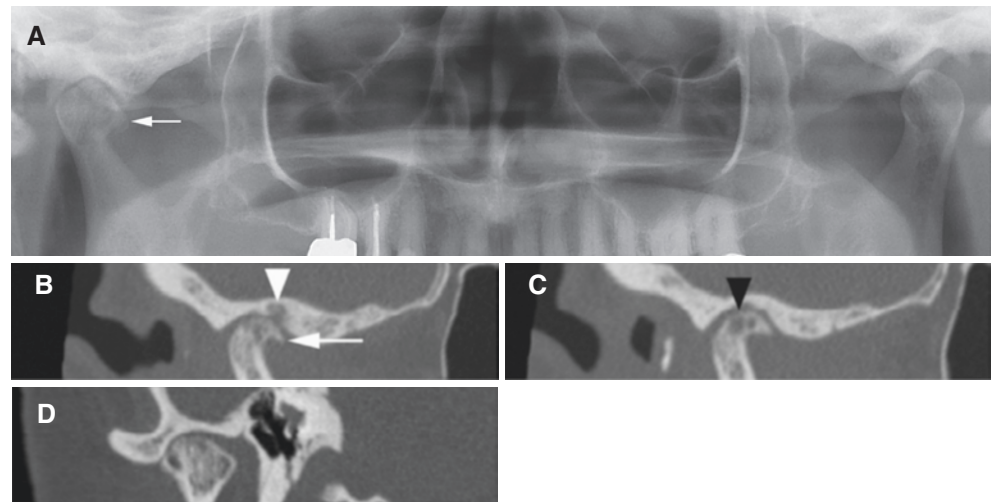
Osteoarthritis, with 5-year follow-up; female 37-year-old at baseline (A, B, C, D, E, F, G). (A) Panoramic view shows sclerotic and flattened left mandibular condyle (arrow). (B) Axial and (C, D) oblique sagittal CT images show normal right joint (B, C) and osteoarthrotic left joint (B, D); arrowhead condylar erosion, arrow condylar sclerosis. (E) Oblique sagittal PD-weighted, (F) oblique sagittal T2-weighted, and (G) oblique coronal T1-weighted MRI show sclerosis (reduced signal
